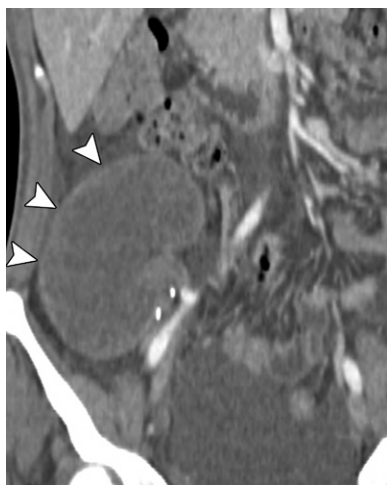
Complete renal allograft infarction due to rejection-related vascular thrombosis 7 years after transplantation. Coronal contrast-enhanced CT image shows diffuse enlargement and nonenhancement of the right lower quadrant transplant kidney, with the “cortical rim sign” of thin capsular enhancement (arrowheads), a feature of infarction.
